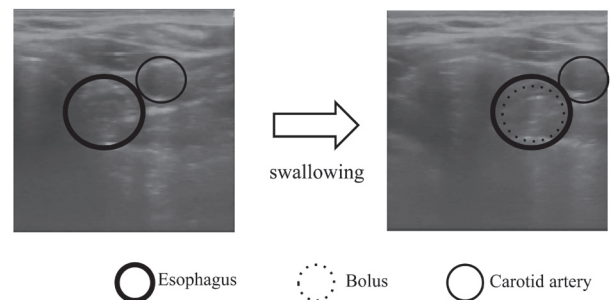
Ultrasound images around the esophagus when the ultrasonic probe was positioned on the skin over the thyroid gland.
